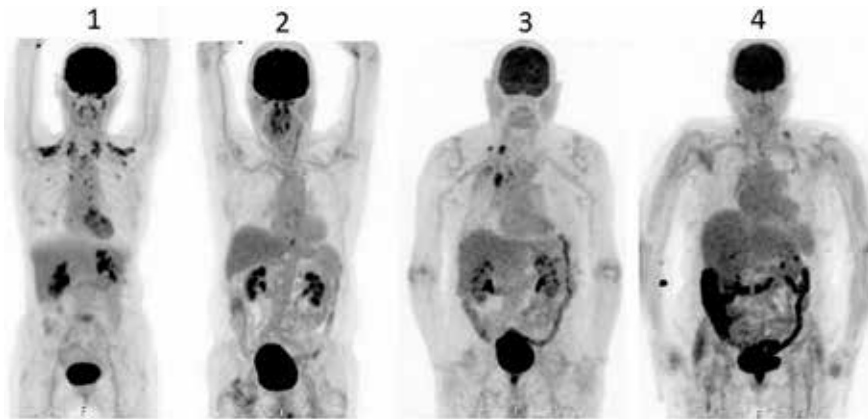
[ $^{18}\text{F}$ ]FDG PET/CT images of four patients from our study with different grades of [ $^{18}\text{F}$ ]FDG uptake in the colon, from left to right, corresponding to the four-point scale method of Gontier et al. [1]
